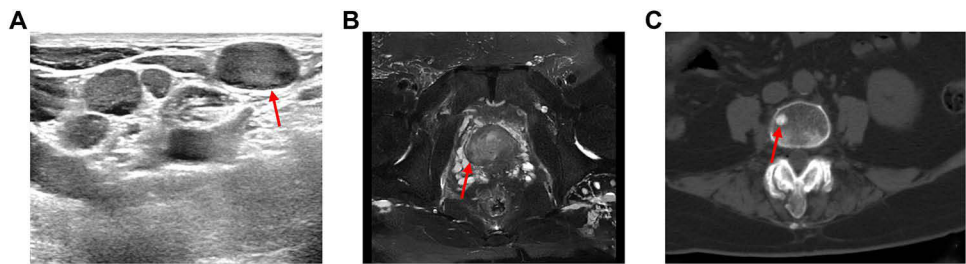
Diagnostic images of the case. (A) Cervical ultrasonography showing enlarged left supraclavicular lymph nodes (indicated by arrows) that were secondarily involved by metastatic carcinoma. (B) Prostate magnetic resonance imaging (MRI) shows a PI-RADS 5 lesion (indicated by arrows) in the transition zone. (C) Vertebral MRI demonstrating abnormal signals consistent with bone metastases in the spine (indicated by arrows).
